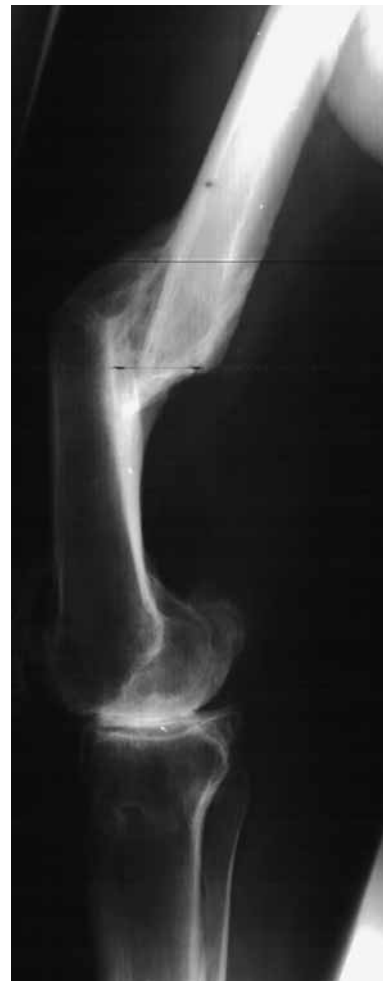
Right knee, preoperative lateral radiograph.
